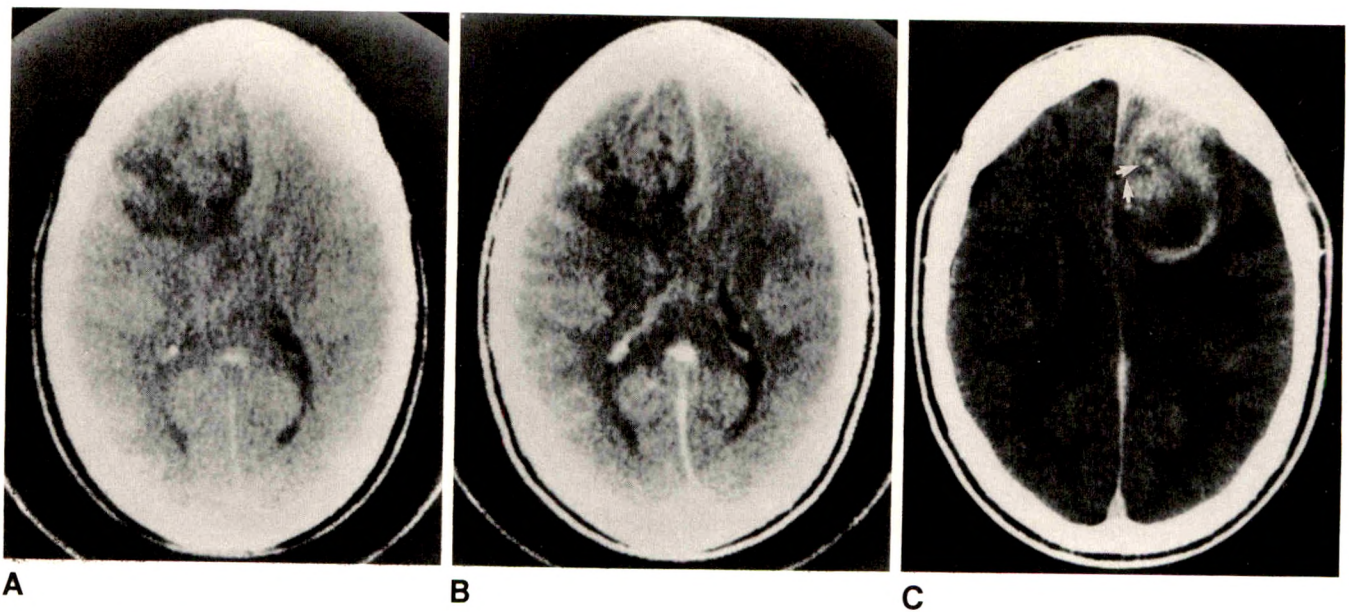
A and B, Pre- (A) and post- (B) contrast CT of a pure intermediate-grade oligodendroglioma. Contrast enhancement of the tumor is mild and poorly defined.
